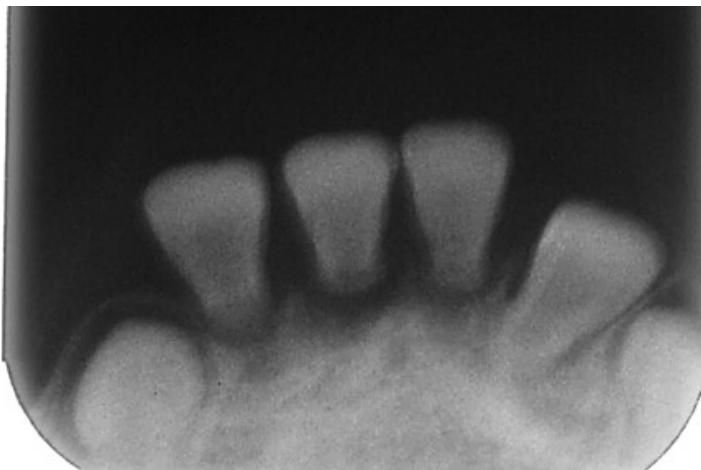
Periapical radiography: At the age of three. Presence of incisors and alteration in root formation.
